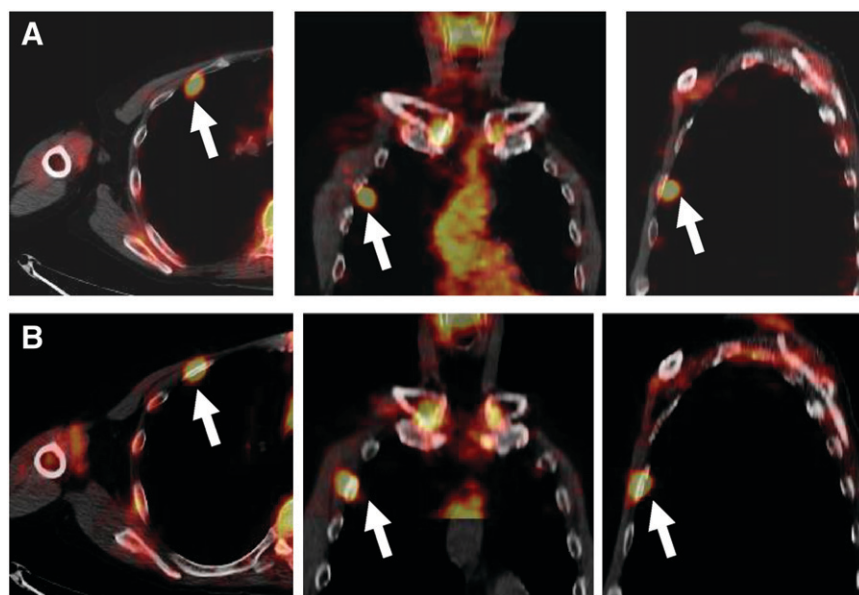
Transaxial, coronal, and sagittal views of clinical (A) and DIBH (B) fused PET and CT images are shown. Arrows point to a lesion in rib, based on CT images. PET lesion appears partially in lung on clinical images and just partially matching CT lesion because of respiratory motion. DIBH technique allowed improvement of coregistration between PET and CT and lesion localization.
